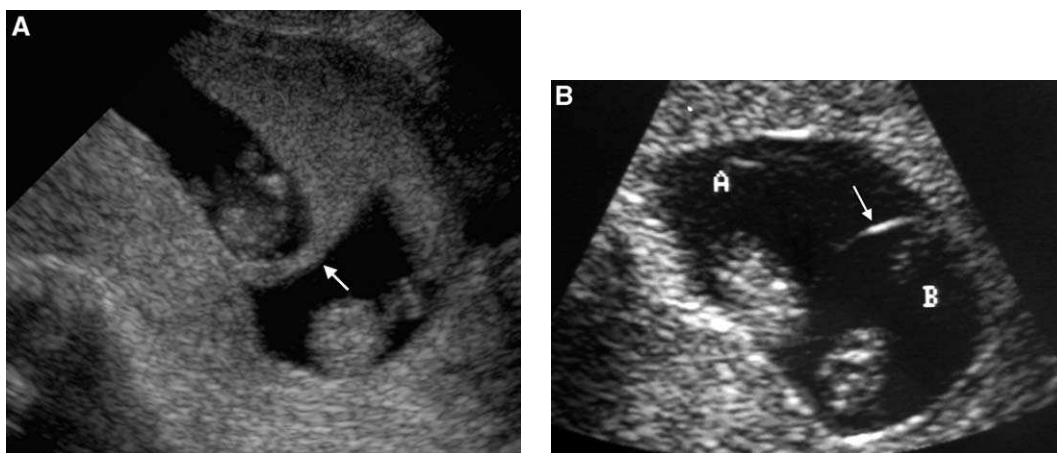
First trimester obstetric sonograms with comparison of membrane thickness. (A) In this case, a thick membrane (arrow) is seen, which indicates dichorionic—and therefore diamniotic—gestation. (B) In comparison, a thin intertwin membrane (arrow) is seen in this monochorionic diamniotic pregnancy. This thin membrane represents two opposing layers of amnion.
